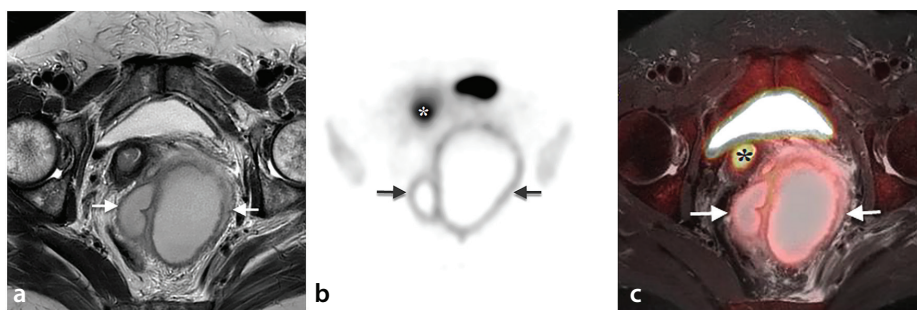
Pelvic abscess. The axial T2-weighted magnetic resonance image (MRI) (a) shows a walled-off biloculated fluid-filled collection (arrows) displaying moderately high signal intensity content in keeping with pus. The axial positron emission tomography (PET) (b) and axial fused PET/MRI (c) show intense peripheral fluorodeoxyglucose (FDG) uptake (arrows) and central photopenia, consistent with abscess. Surgical pathology revealed fibrous tissue with mixed inflammation and abscess formation. The uterine lesion seen as an FDG-avid focus [asterisks in (b) and (c)] on the right anterior aspect of the abscess was diagnosed as serous endometrial cancer invading the cervix uteri.
